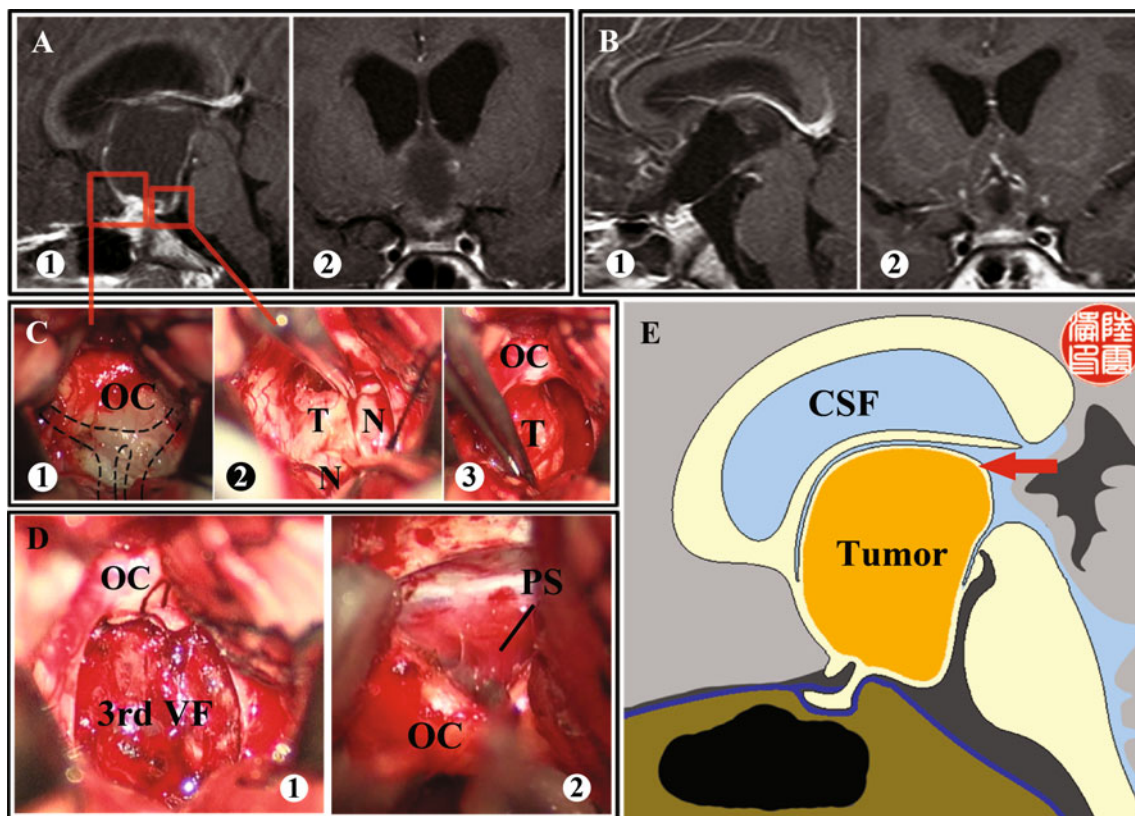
Showing tumor adherence pattern “b” to the 3rd VF. a Presurgical MRI scan (① coronal; ② sagittal). b Postsurgical MRI scan (① sagittal; ② coronal). c Intraoperative findings. Exposure of the LT, the tumor was found behind the AcoA, which has been dissected (dotted lines show the artery’s original location (①)). Well-defined interface between tumor and third ventricular walls can be traced along the tumor capsule though it adherents to the nervous layer widely (②). With tumor separation, the pedicle side of tumor was observed being adherence to the 3rd VF tightly (③). d After tumor
